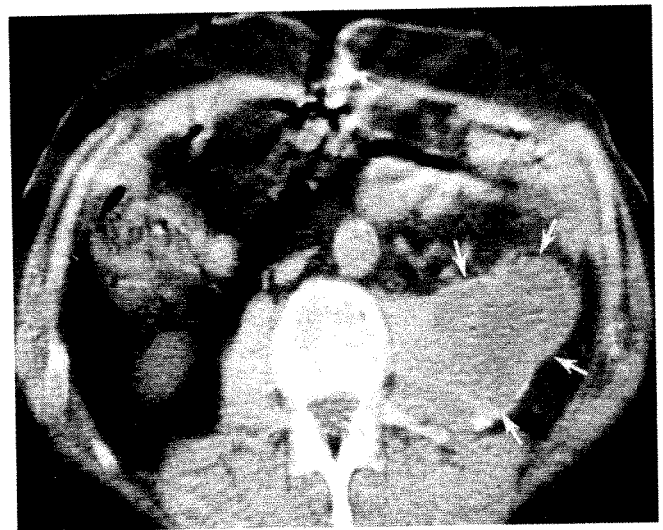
64-year-old man with dull ache in left flank 2 years post left nephrectomy for carcinoma. No mass palpable; conventional radiographic studies normal. CT scan showing large mass in left retroperitoneum (arrows) contiguous with left psoas muscle. Mass, consistent with recurrent carcinoma, has central low attenuation coefficients suggesting some necrosis.
